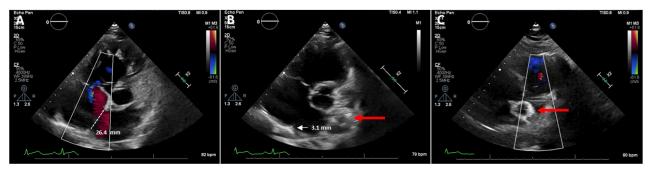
Two-dimensional TTE, basal parasternal short-axis views. (A) Right ventricle- (RV-) focused view with color-flow Doppler, systolic phase, demonstrates the dilated RV and right atrium with a large secundum ASD with left-to-right shunt and mild tricuspid regurgitation. (B) Without color-flow Doppler, the deficient posterior rim (*white arrow*) and absence of an aortic rim are demonstrated. A circular echodense object (*red arrow*) concerning for the suspected dislodged ASDO in the left atrium or main pulmonary artery is seen. (C) Right ventricular outflow tract-focused view, diastolic phase with color-flow Doppler, demonstrates the dislodged ASDO device (*red arrow*) within the pulmonary artery.
